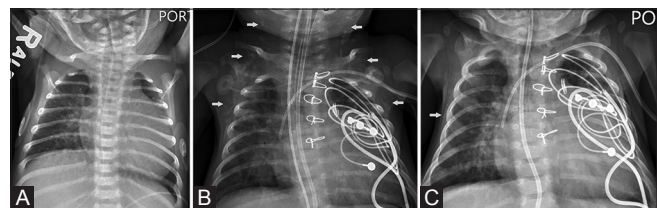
(A-C): Ex full term infant with double-outlet right ventricle, heterotaxy syndrome with polysplenia who underwent PDA ligation, pulmonary artery banding, and epicardial pacemaker placement. Severe bradycardia and hypotension episode preceded appearance of soft tissue calcification by 3-4 weeks. Chest radiograph at 4 days old (A) demonstrates absence of soft tissue calcifications. Chest radiograph at 6 weeks (B) demonstrates significant bilateral soft tissue calcifications in the bilateral axillae, peri-scapular, peri-clavicular regions (white arrows). Chest radiograph at 9 weeks (C) demonstrates near complete interval resolution of soft tissue calcifications
